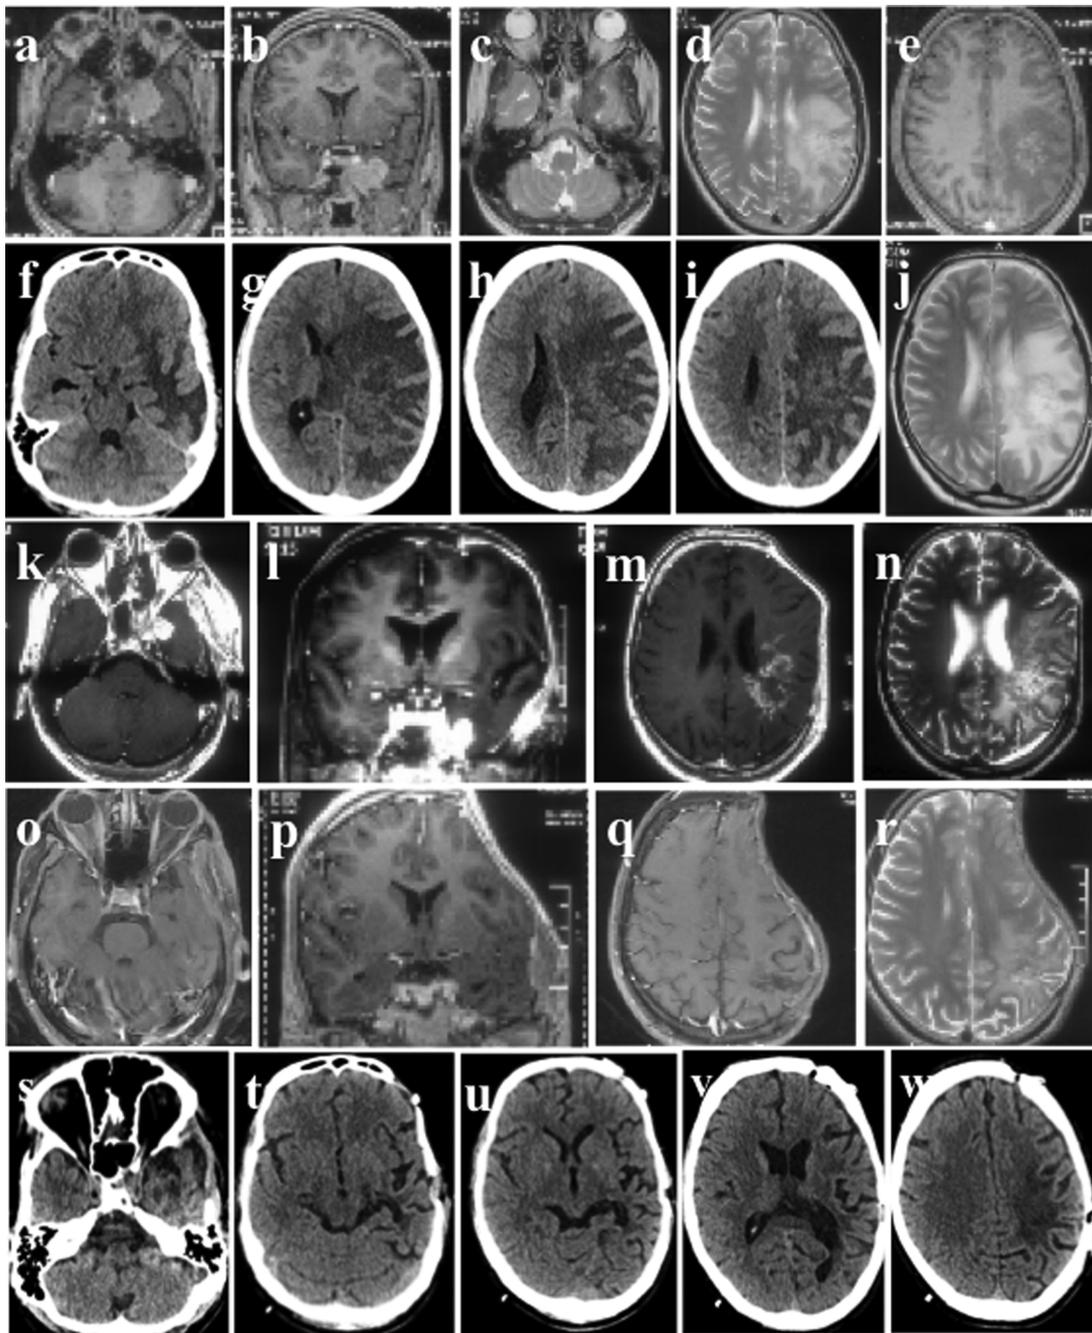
A 30-year-old male patient (no:16 in Table 4) presented with altered sensorium and right hemiparesis. MRI revealed left medial temporal lesion with cavernous sinus involvement and left fronto-parietal lesions. Both lesions were hypo intense on T2W images and showed contrast enhancement (a–j). The fronto-parietal lesion was associated with significant peri-lesional edema and mass effect. The patient underwent decompressive craniectomy and biopsy from temporal lesion and received anti fungal therapy. Contrast MRI at 3 months shows reduction in size of temporal lesion and peri-lesional edema (k–n). MRI at one year shows complete resolution of both the lesions and peri-lesional edema (o–r). Patient underwent cranioplasty (s–w) and is symptom free at 16 months follow up.
